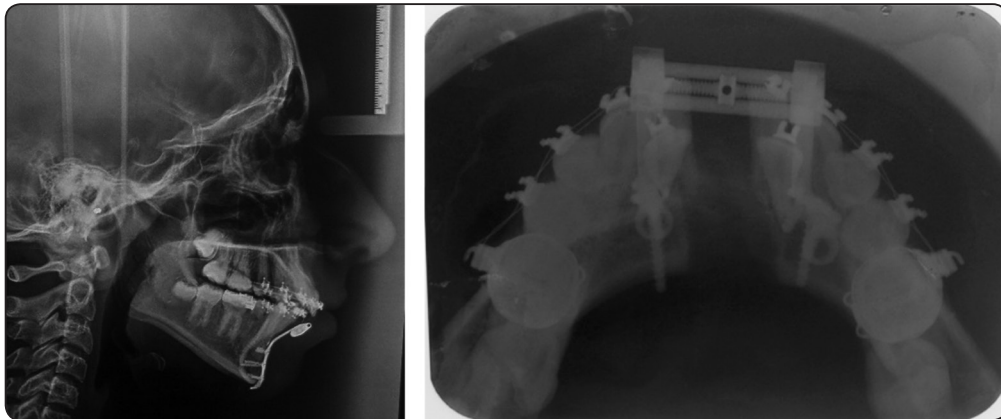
Lateral cephalometric radiograph and occlusal radiograph at the end of distraction
